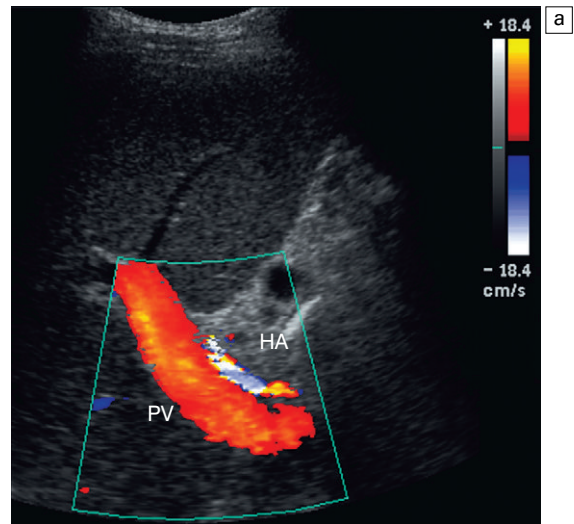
Oblique colour Doppler images of the porta hepatis. (a) The hepatic artery (HA) accompanies the portal vein (PV) and bile ducts. With the colour scale appropriately set for the slow flow within the portal vein, hepatic arterial flow often reveals colour aliasing during systole. (b) With biliary dilatation colour Doppler provides clear discrimination between vessels and ducts (arrow).
